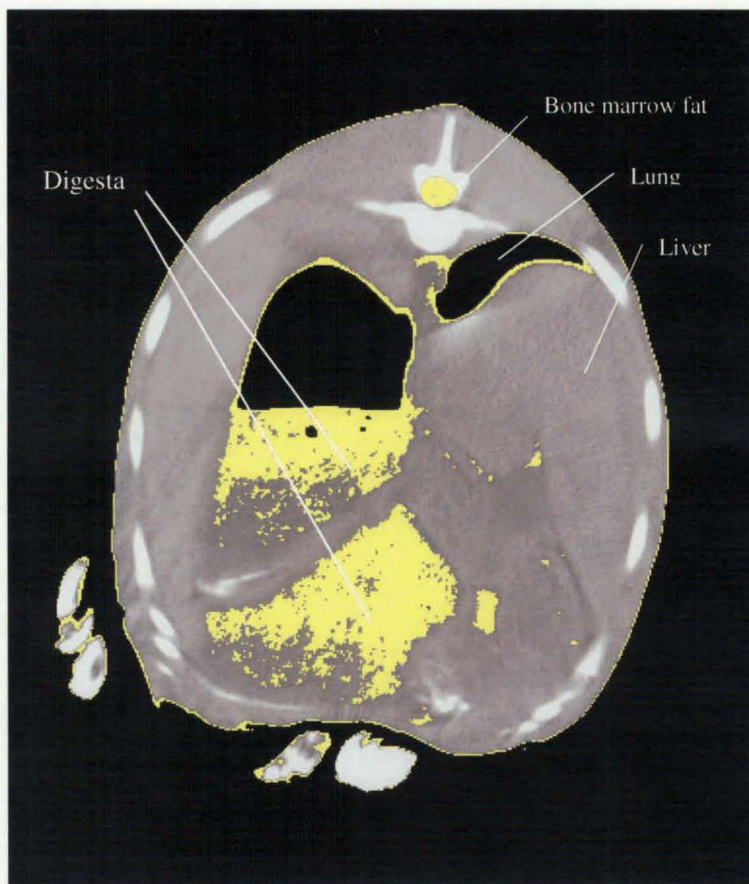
A CT image in the abdominal region of a deer with the pixels in the grey scale range associated with adipose highlighted in yellow.
